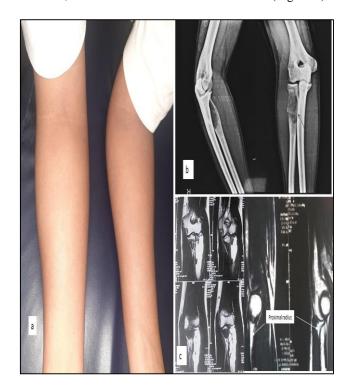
(A-C): clinical picture of elbow showing swelling at proximal radius; plain radiograph showing eccentric ballooning expansion and radiolucency with septate loculations; MRI of involved lesion showing multiple blood-filled cystic space lesion within the metaphysis and appeared expansile with surrounding cortical thinning on T2 weighted of coronal and sagittal.
